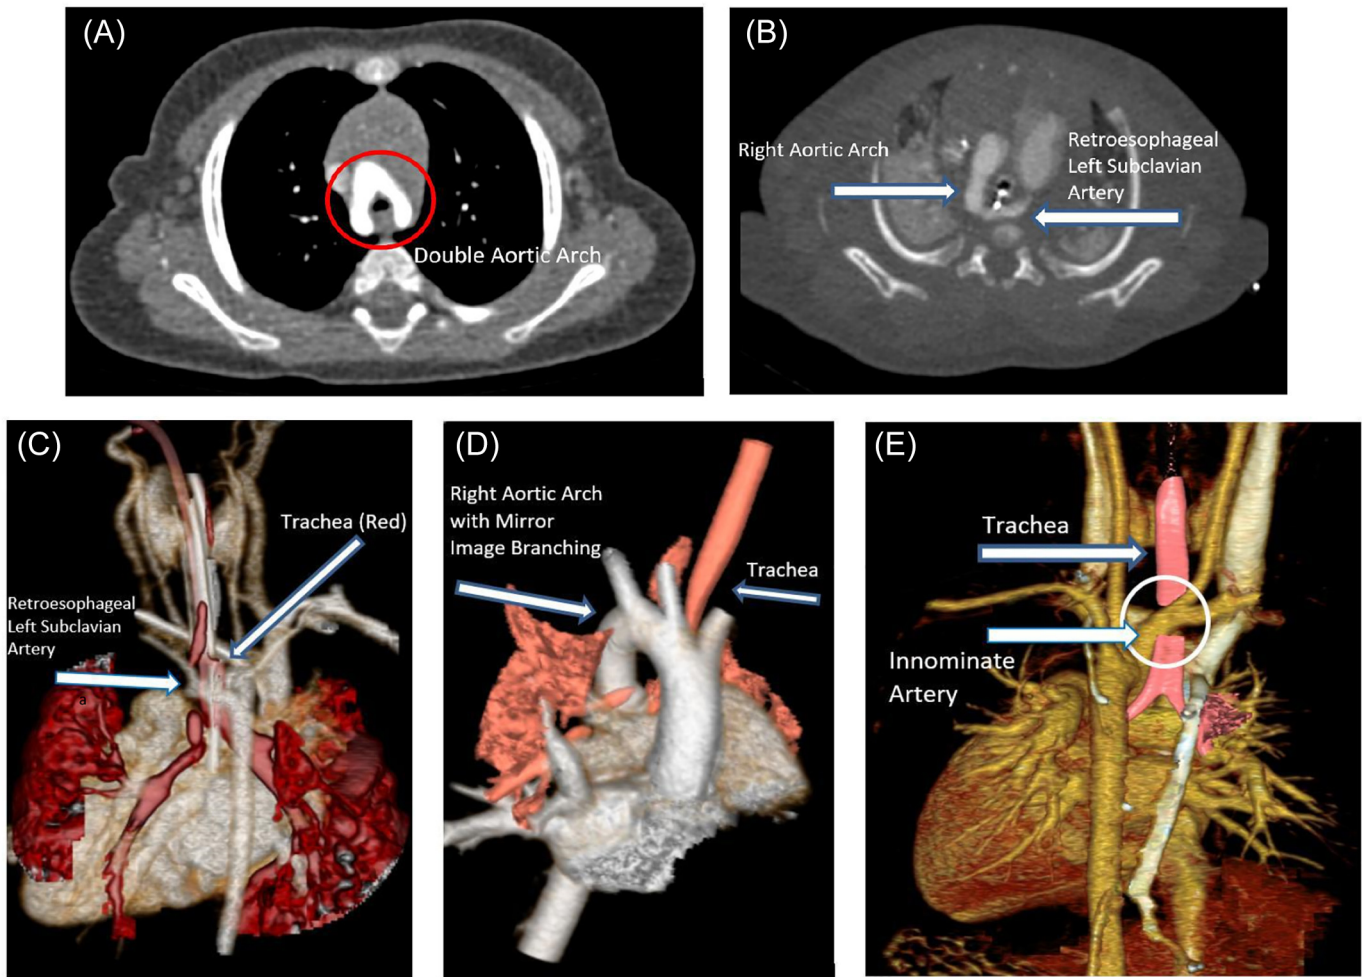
(A–E) Axial CT and 3D reconstructed images of great vessel anomalies identified. (A) Axial imaging of a balanced double aortic arch as it surrounds the trachea. (B) A patient is noted to have a right aortic arch with a retroesophageal left subclavian artery on axial CT, whose relationship to the trachea is better identified on 3D reconstruction (C). (D) This patient has a right aortic arch with mirror image branching that can best be seen with 3D reconstruction. (E) The posterior view of a MDCT scan with 3D reconstruction shows significant innominate artery compression, causing complete collapse of the mid trachea (T2).
